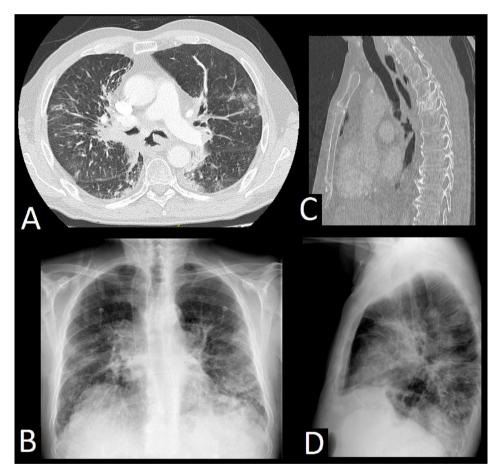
(A and C) Thoracic computed tomography showing a bronchoesophageal fistula involving the left main bronchus. (B and D). Chest radiography after endoscopic intervention shows an esophageal stent.
